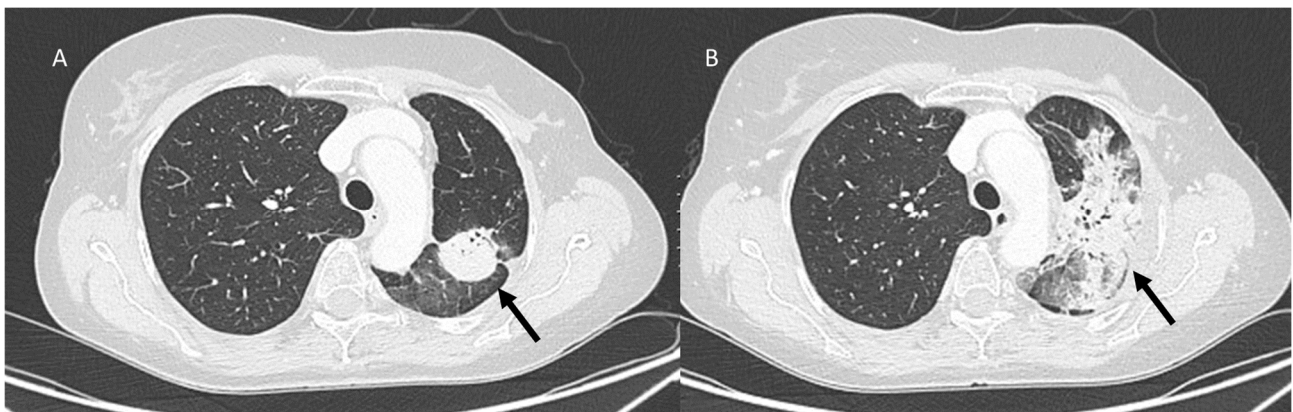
CT assessment of radiation pneumonia RP in RT-treated lung cancer. In (A), ground glass opacities (arrow) at about 8 weeks following completion of radiotherapy. In (B), consolidative pattern (arrow) at 12 weeks.
